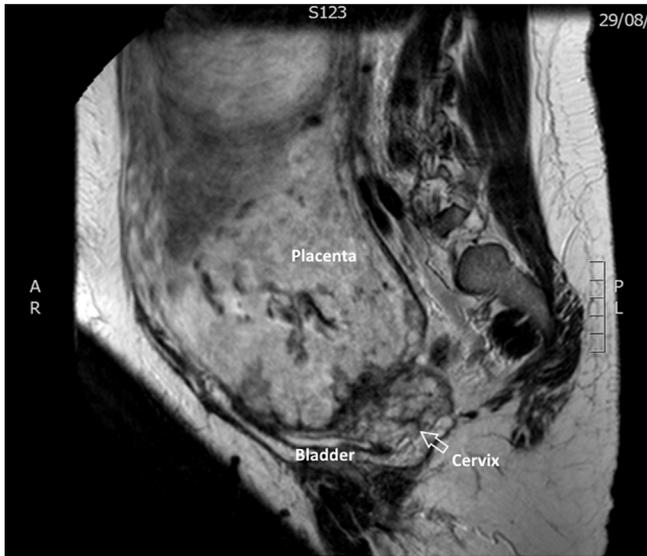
Magnetic resonance imaging. The placenta is localized above the cervix (placenta praevia). There are dark intra-placental bands and the placenta is heterogeneous in texture just above the bladder wall, however the bladder wall itself did not seem to be involved.
